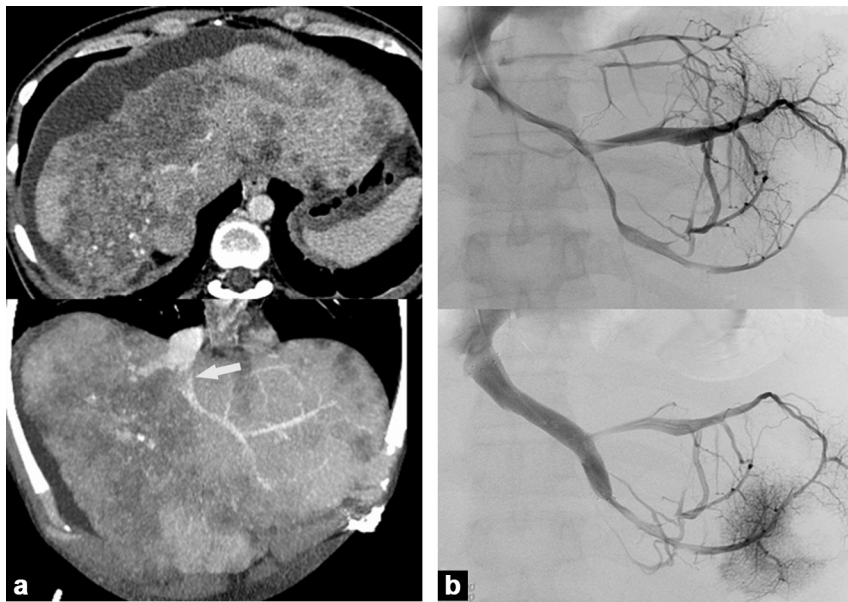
Recurrent hematemesis due to rupture of esophageal varices in the patient with colonic carcinoma and liver extension: a: enhanced CT, axial view (upper image) and frontal MIP reconstruction (lower image). Extensive hepatic tumor infiltration with obstruction of the right and middle hepatic veins and ostial stenosis of the left hepatic vein (arrow); b: left hepatic vein angioplasty through the jugular vein. Deployment of a metal stent releases the proximal stenosis.
